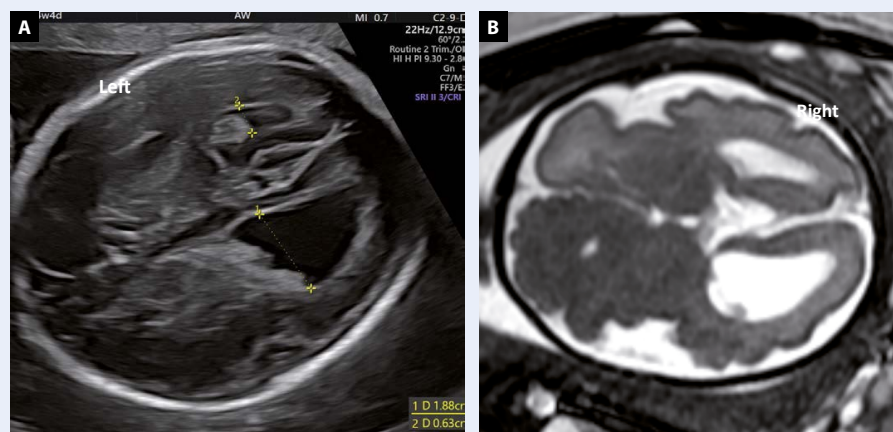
Hemimegalencephaly. Transventricular plane showing enlarged right cerebral hemisphere and the unilateral right side ventriculomegaly with midline shifted to the left. (A) 2D transabdominal ultrasound scan at 24 gestational weeks; (B) foetal MRI at 29 gestational weeks, FIESTA, axial plane
